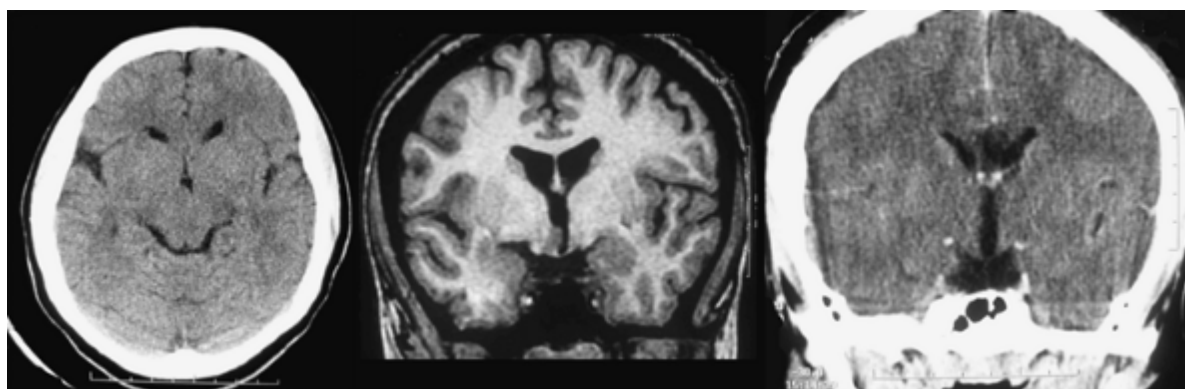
A 16-year-old girl with seizures since the tenth day of birth characterized by behavioral arrest, oral and upper limb extremity automatisms, ictal speech and incessant cry or laughter for 2 minutes, and urinary incontinence occurring approximately ten times per day. Electroencephalography (EEG) revealed bitemporal epileptiform discharges, and video-EEG monitoring could not localize seizure onset. The patient underwent hypothalamic hamartoma resection by the transcallosal anterior forniceal approach at the Sree Chitra Tirunal Institute for Medical Sciences and Technology, Trivandrum, India, in November 2003, and has been seizure free since then except for a few auras of fear. Axial and coronal magnetic resonance imaging sequences show the lesion abutting the right lateral wall of the third ventricle; postoperative computed tomography shows complete lesion resection.
